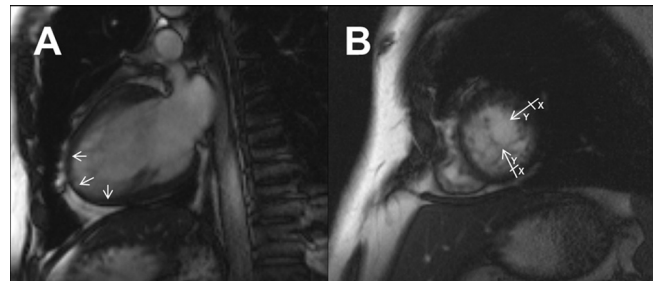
Two chamber (A) and short axis (B) steady state free precession (SSFP) MR images showing a typical pattern of noncompacted myocardium predominantly of the left ventricle. Ratio of noncompacted (Y) to compacted (X) area was 2.7.
